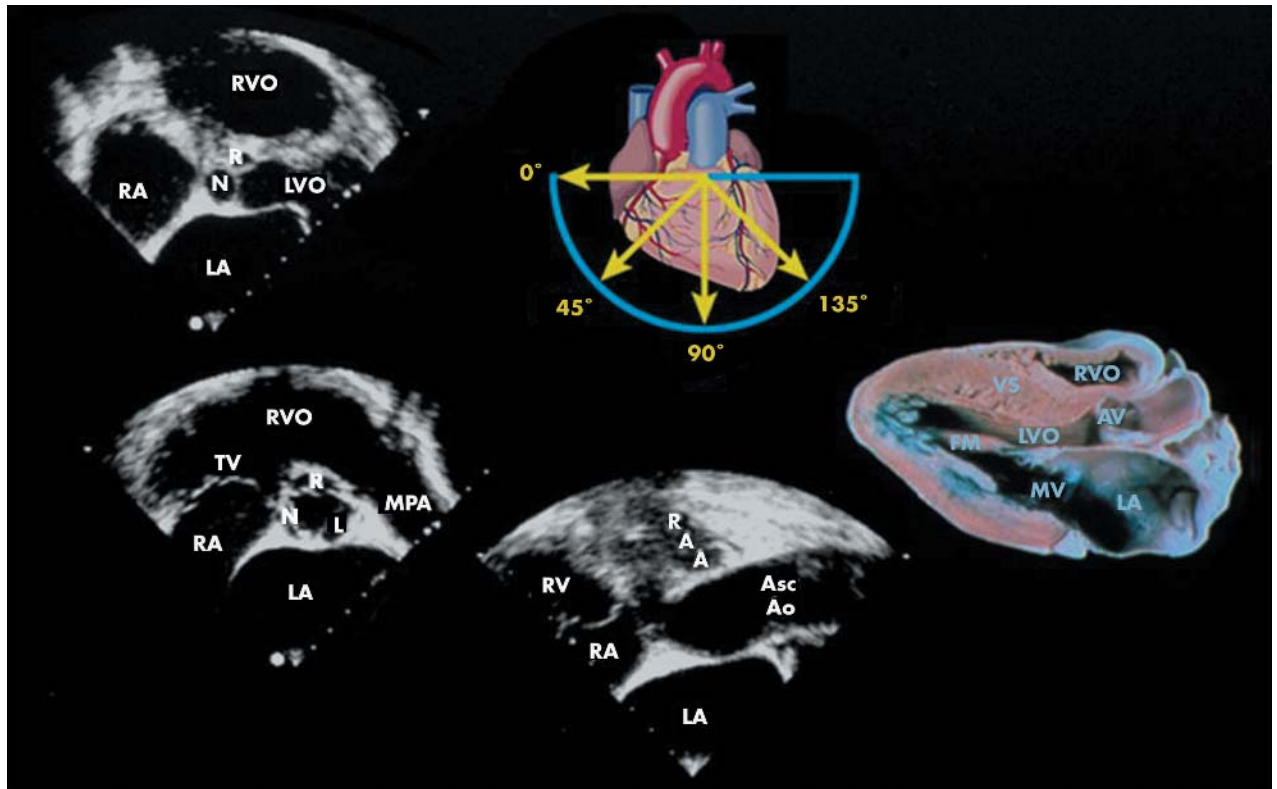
Multiplane transoesophageal echocardiographic (TOE) views (0° , 45° , 90° , and 135°) obtained from mid oesophagus. Asc Ao, ascending aorta; LA, left atrium, LV, left ventricle; LVO, left ventricle outflow; MPA, main pulmonary artery; MV, mitral valve; RA, right atrium; RAA, right atrial appendage; RV, right ventricle; RVO, right ventricular outflow; TV, tricuspid valve; VS, ventricular septum; R, L, and N, right, left and non-coronary aortic sinus.
